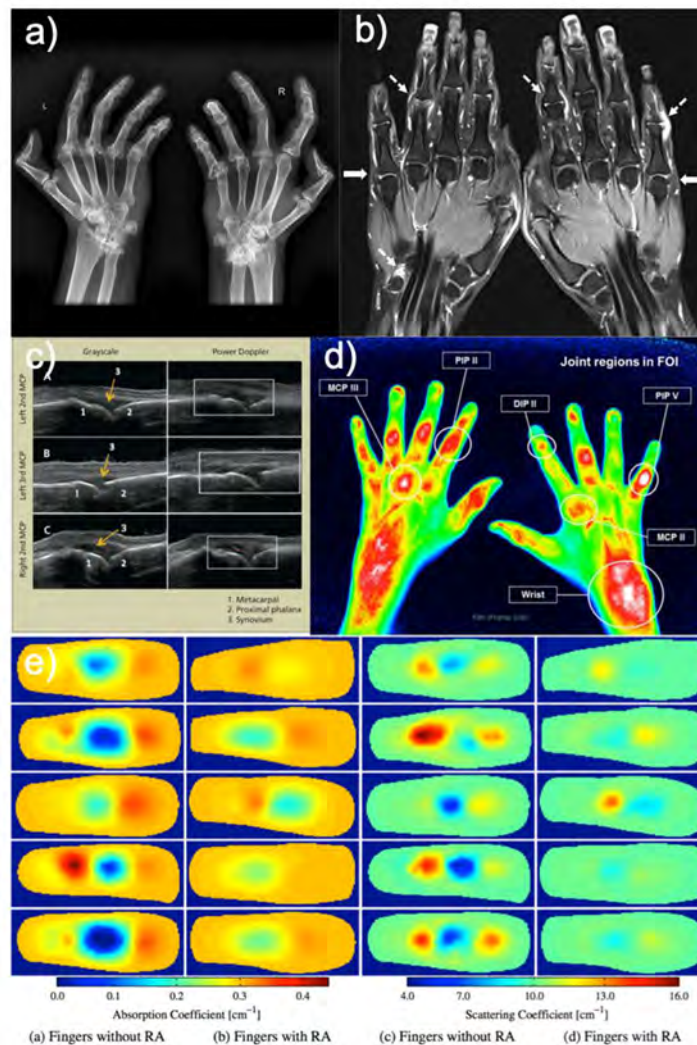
Examples images for clinical and experimental methods of imaging the effects of rheumatoid arthritis in the hand joints. Figures a-e depict x-ray (48), MRI (49), ultrasound (50), near-infrared fluorescence imaging (51) and frequency-domain diffuse optical tomography (52) respectively, reproduced from the cited sources.
